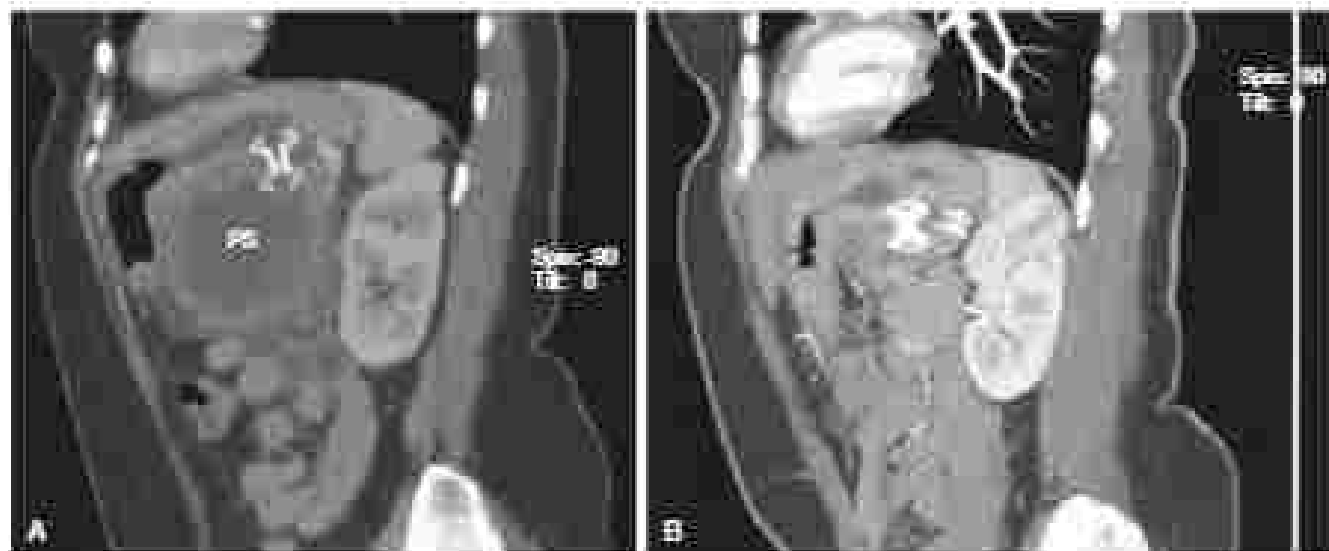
(A) Coronal computed tomography (CT) scan after endoscopic cystogastrostomy shows fluid in gas pocket between the stomach and pseudocyst. (B) CT scan 4 weeks later shows collapsed drainage with collapse of pseudocyst (P).
